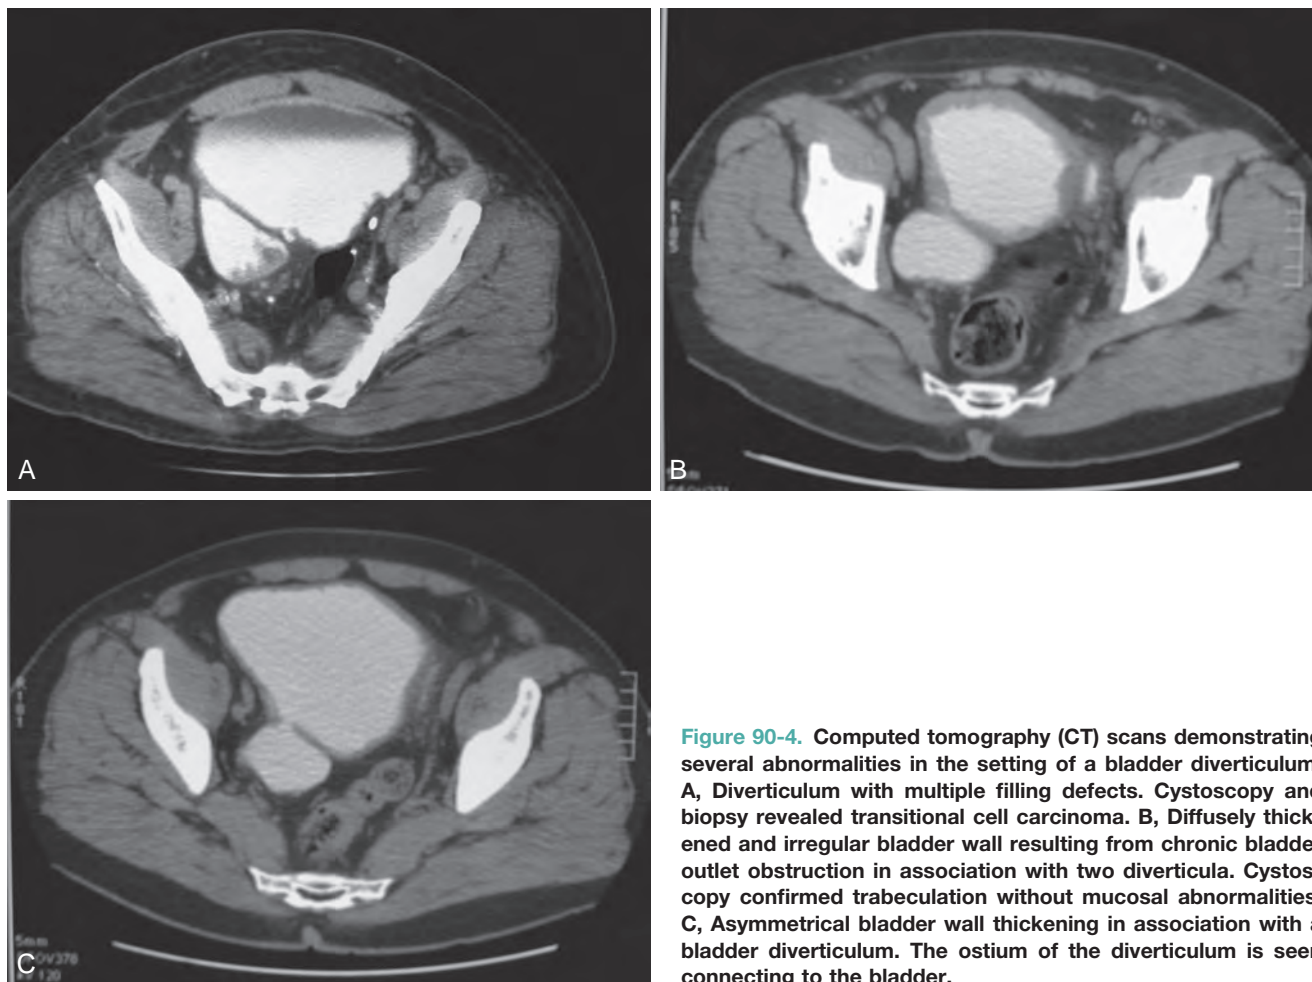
Computed tomography (CT) scans demonstrating several abnormalities in the setting of a bladder diverticulum. A, Diverticulum with multiple filling defects. Cystoscopy and biopsy revealed transitional cell carcinoma. B, Diffusely thickened and irregular bladder wall resulting from chronic bladder outlet obstruction in association with two diverticula. Cystoscopy confirmed trabeculation without mucosal abnormalities. C, Asymmetrical bladder wall thickening in association with a bladder diverticulum. The ostium of the diverticulum is seen connecting to the bladder.
